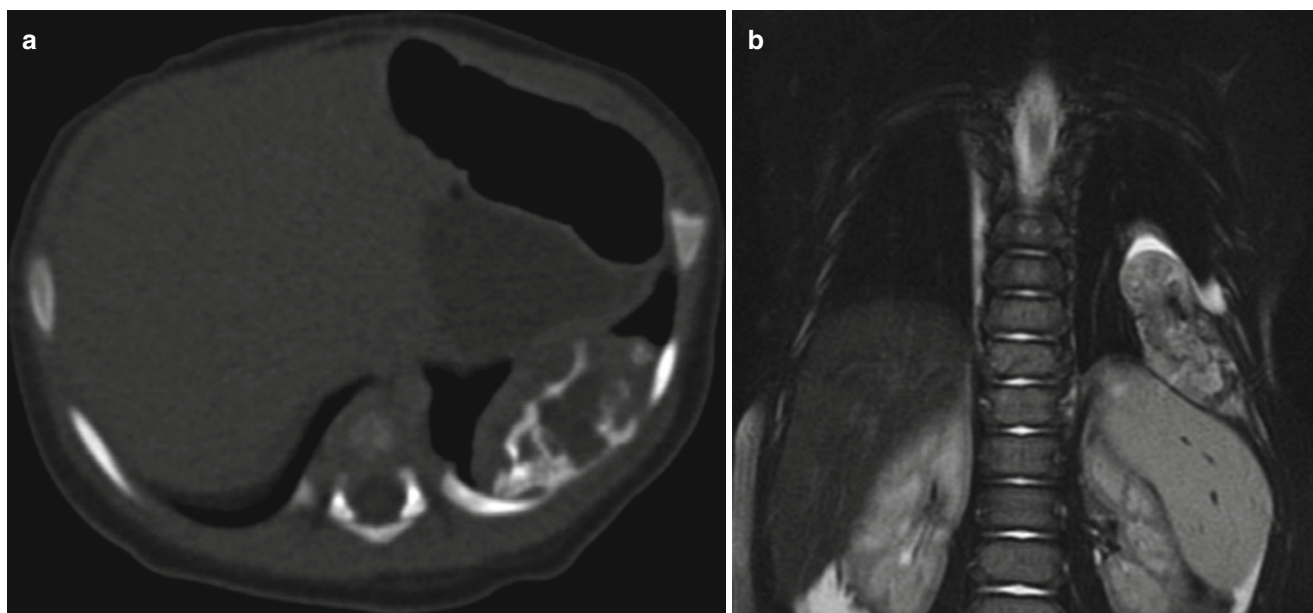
Antenatal ultrasound revealed a calcified chest mass in this infant. Chest radiograph at birth showed partially calcified lesion in the chest and CT scan (a) was obtained to better define the lesion. It demonstrated a lesion arising from the ventral aspect of the 10th rib which was heterogeneous with areas of internal spiculated or plate-like ossification/calcification throughout the mass which was felt to be consistent
